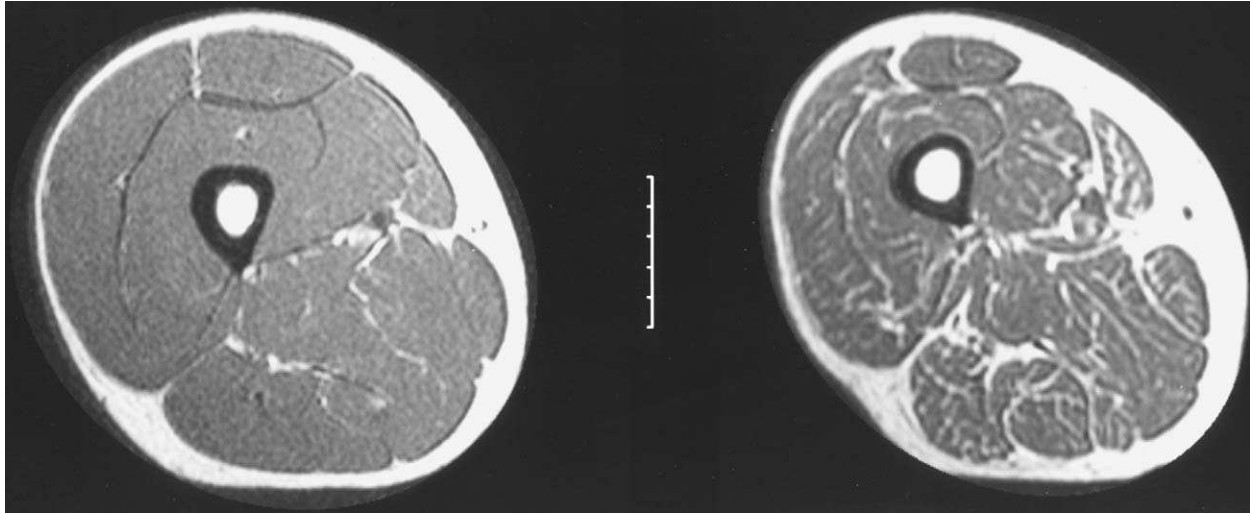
Magnetic resonance images taken at the midhigh level in 2 subjects with similar body mass and height: left, 25-year-old male; right, 65-year-old male. Note the lesser muscle (gray) area and greater fat (white) area in the older subject.
